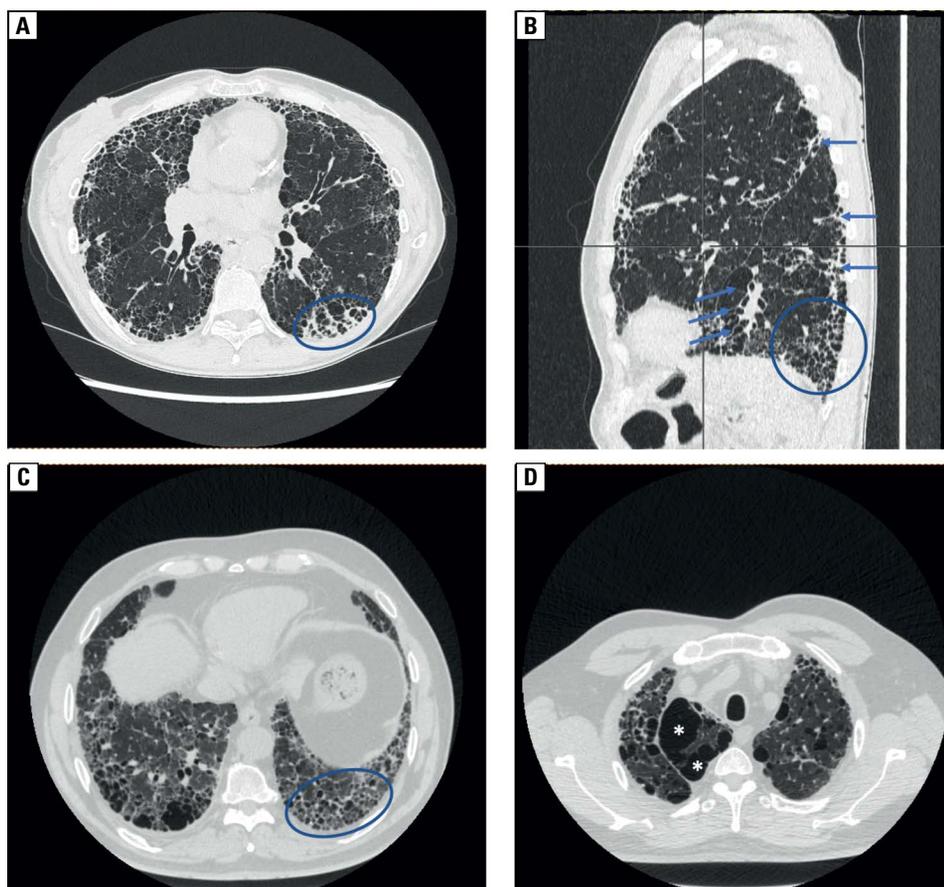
High-resolution computed tomography images depicting: A and B — usual interstitial pneumonia; C and D — usual interstitial pneumonia concomitant to emphysema (from Radiology Department, N. Barlicki University Teaching Hospital N° 1 in Lodz). Honeycombing located subpleurally at lung bases (blue ovals), traction bronchiectasis (blue arrows), concomitant emphysema (white asterisks)
